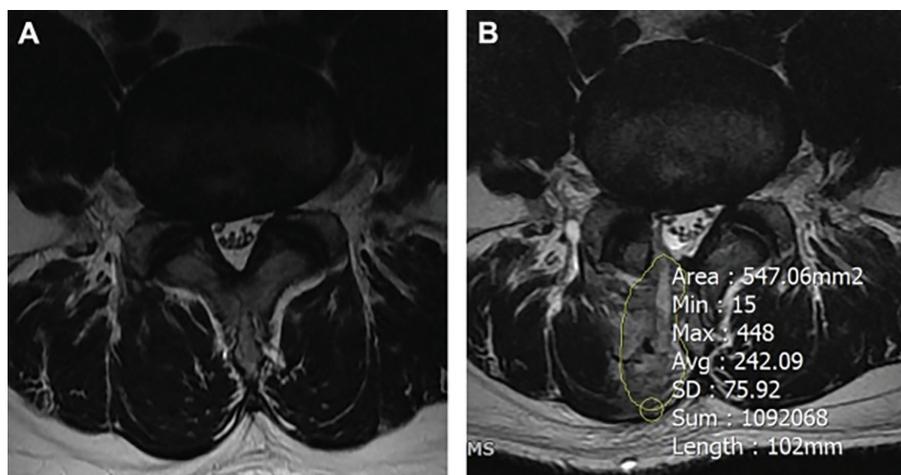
Comparison of the cross-sectional area (mm²) of high-intensity regions in the paraspinal muscle at the surgical site. Images from preoperative axial T2-weighted magnetic resonance imaging (MRI) (A) and postoperative MRI (B) are shown
